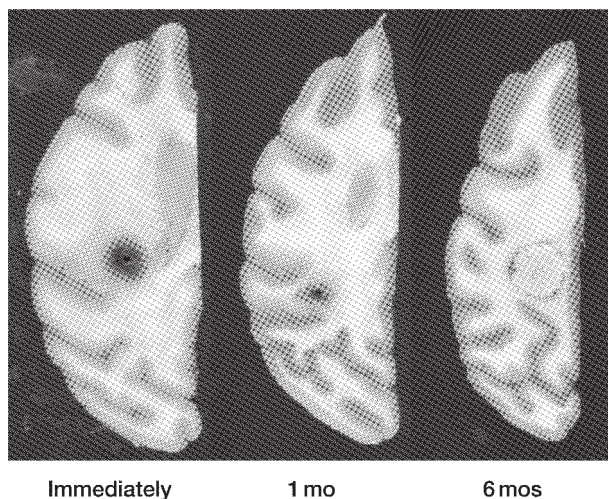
Horizontal sections on the same plane in MR images and CT scans; immediately (left), 1 month (middle), and 6 months (right) after irradiation. The central necrotic zone gradually became more distinct. Immediately after irradiation (left), the borderline between the gray matter and white matter was unclear. This finding indicated massive edema in the white matter.
